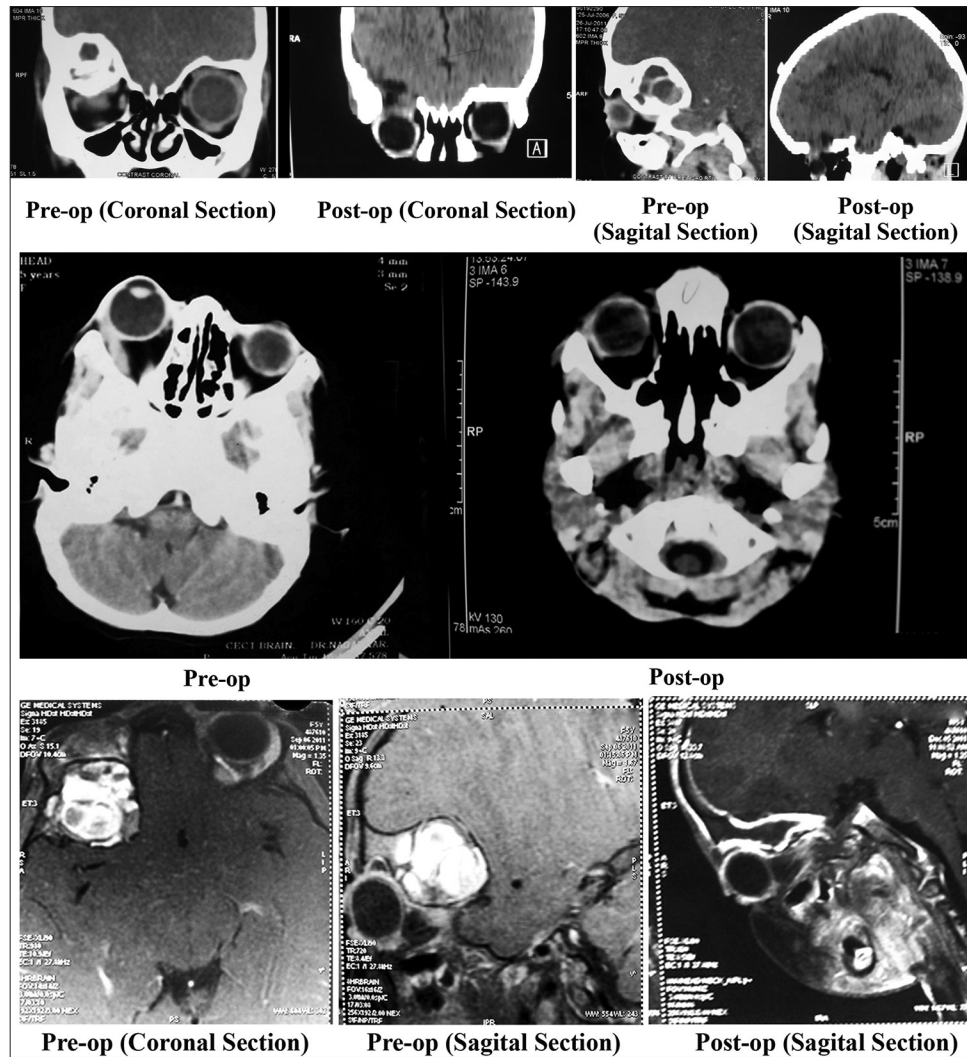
Pre-operative computed tomography (CT) scan image shows an expansile multi-cystic lytic lesion in the roof of right orbit. Post-operative CT scan image shows complete excision of the lesion (coronal sections) (sagittal sections). Post-operative magnetic resonance imaging image showing complete excision of the lesion. Post-operative computed tomography image shows complete resolution of proptosis
